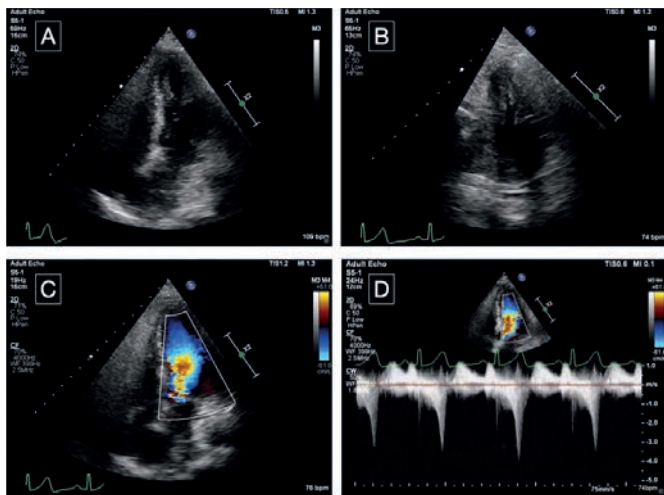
Intra-ventricular obstruction in post-extubation stridor treated with adrenaline. A, B – mid-cavity obliteration in apical views. C – Colour flow Doppler showing Doppler aliasing in the mid-cavity due to turbulent flow. D – Spectral Doppler showing the characteristic late-peaking ‘dagger’ shaped Doppler envelope.
